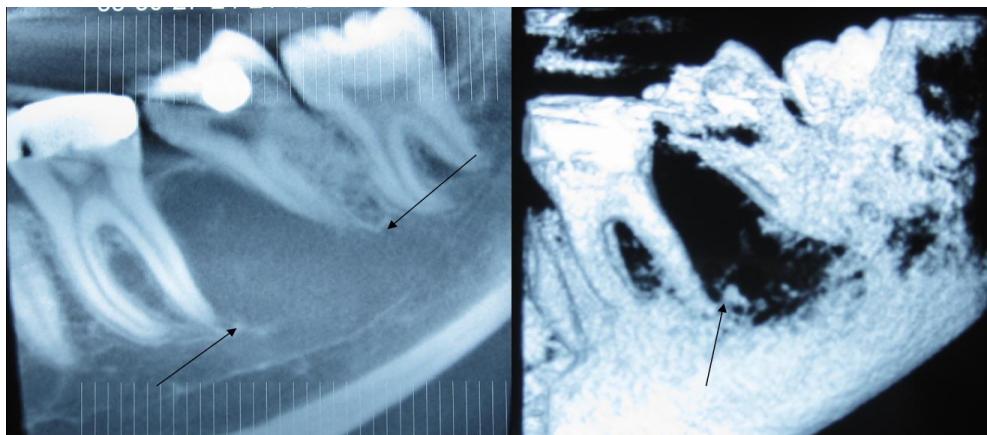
Panoramic radiographic view of CGCG of mandibula.
